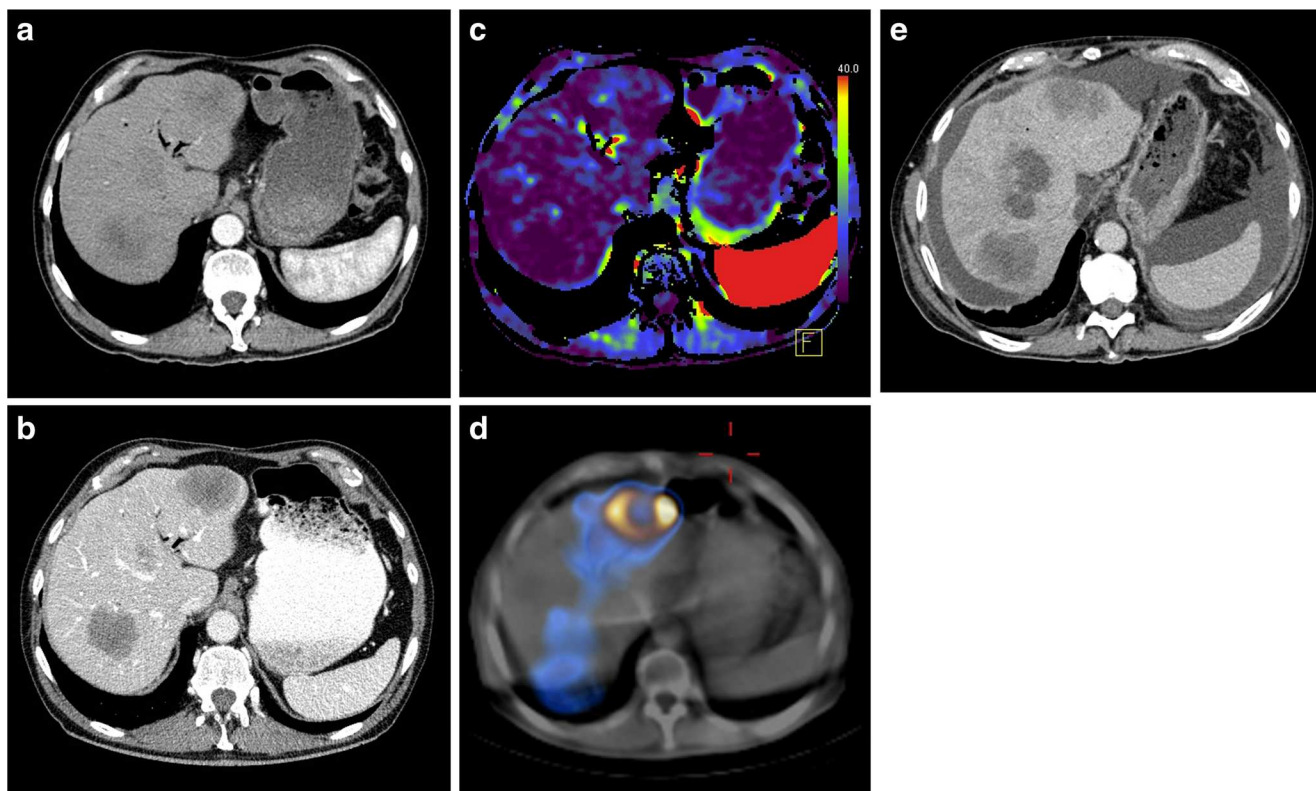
A 73-year-old male patient with metastases from colorectal cancer in both liver lobes. The metastasis had an attenuation on portal venous phase (pvHU) of 58 HU (a) and on arterial phase CT (aHU) of 48 HU (b).
